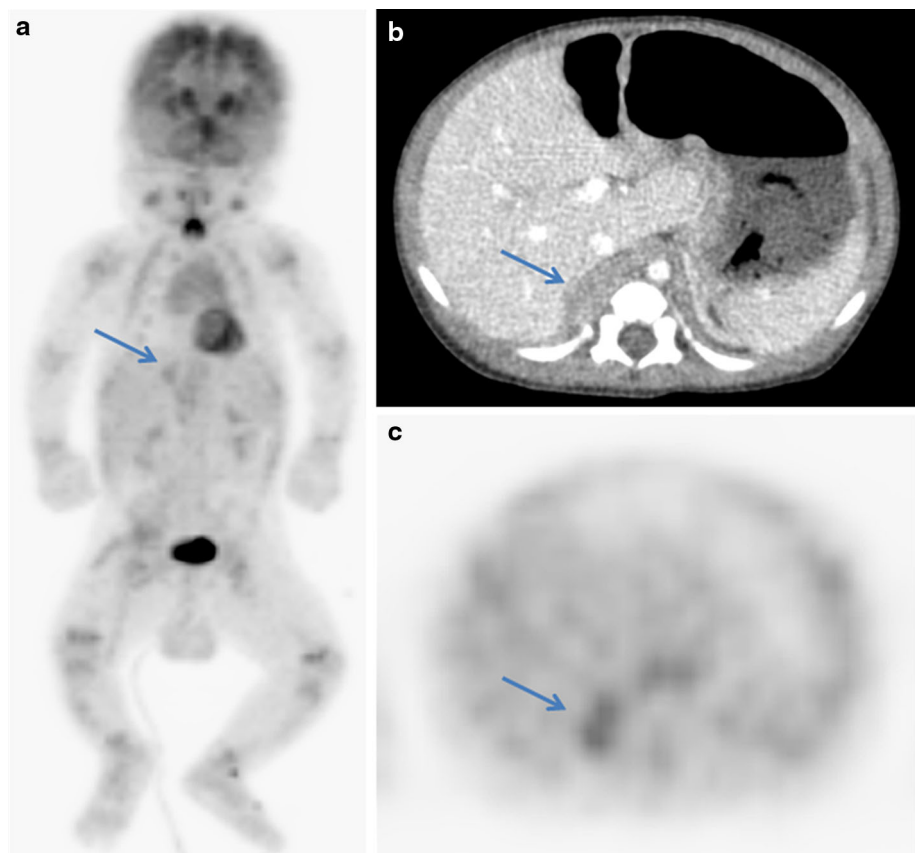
Images of a 7-day-old boy with stage 1 neuroblastoma. a ^{18}F -FDG PET anterior maximum-intensity projection image demonstrates no abnormal focal uptake at abdomen. There are diffuse muscle uptakes, due to crying. b About 3-cm-sized mass in the right adrenal gland is seen on axial CT image. c ^{18}F -FDG PET image shows no definite abnormal hypermetabolism in right adrenal gland
